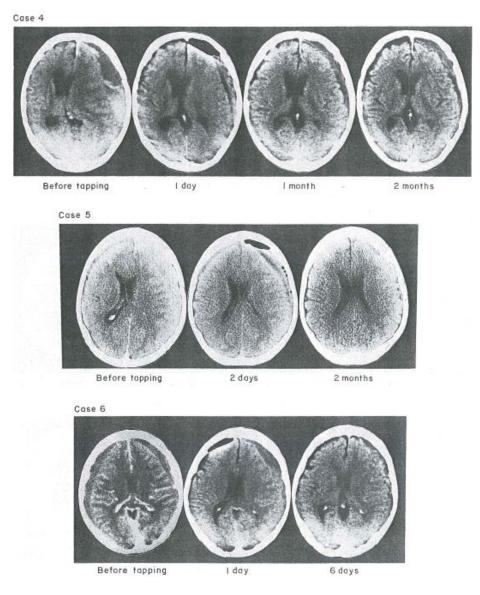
Series of CT Scans in Six Patients.
